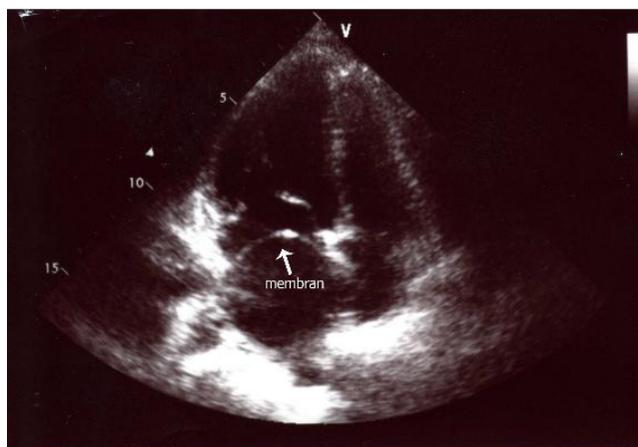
View of the preoperatif transthoracic echocardiography, arrow indicate membrane in the left atrium.
